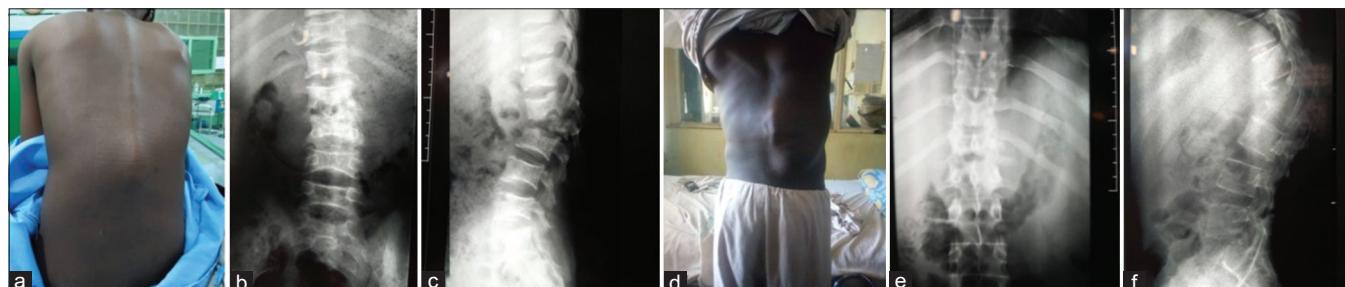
Common clinical features of tuberculosis spine in Nigeria: (a) A painful gibbus in a 16-year-old lady at the thoracolumbar region and (b and c) plain X-ray of the same lady showing complete collapse and disappearance of L2 vertebral body and angular kyphosis with no neurological deficit; (d) another painful thoracolumbar gibbus in a 20-year-old man with paraspinal cold abscess extending to the right lumbar triangle and paraparesis (e and f) plain X-ray of the same man showing wedge collapse fracture of L2 vertebral body and angular kyphosis
